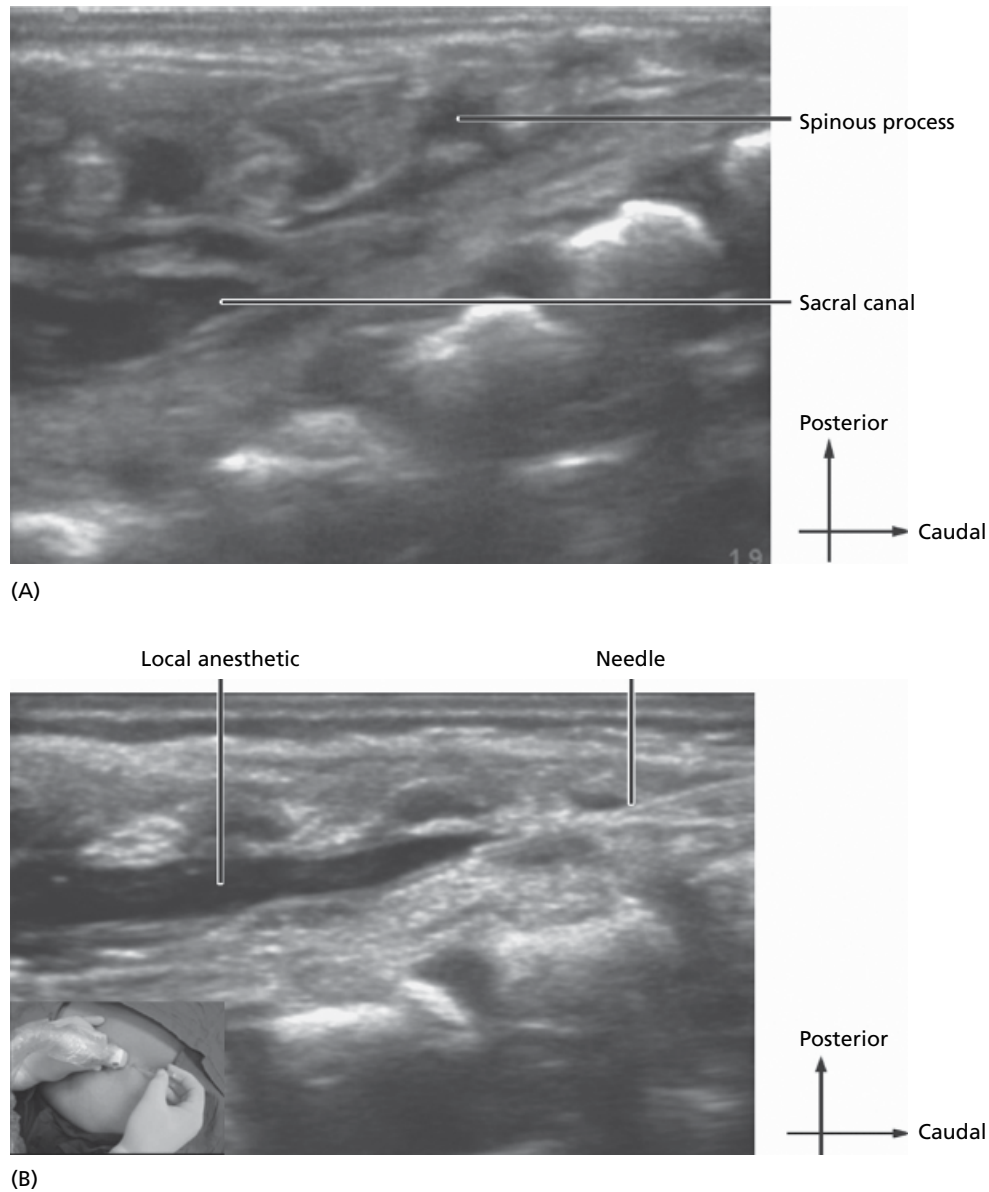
Ultrasound imaging of the caudal region. (A) Before local anesthetic injection. (B) After local anesthetic injection. See text for further details.
